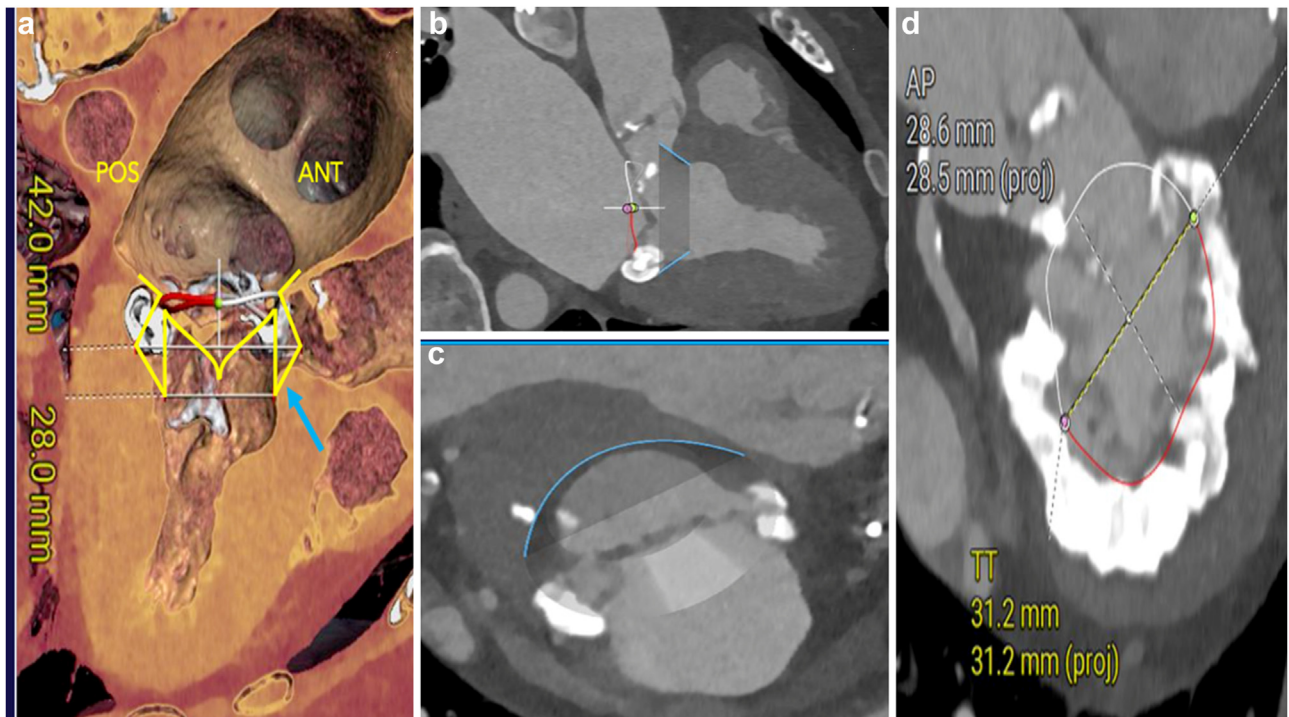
(a-c) CT reconstruction with virtual valve showing neo-LVOT of 0 cm². (d) Cardiac gated CT showing severe MAC. Abbreviations: CT, computed tomography; LVOT, left ventricular outflow tract; MAC, mitral annular calcification.
